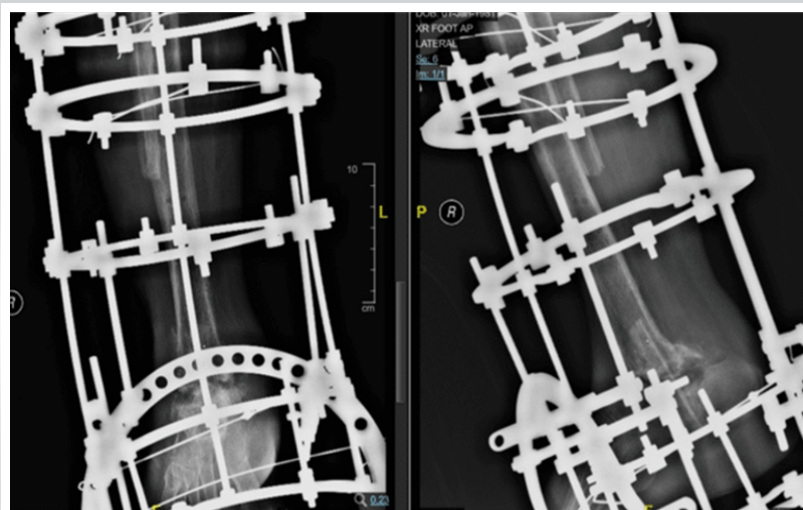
Follow-up anteroposterior and lateral radiographs of the right ankle demonstrating progressive consolidation at the arthrodesis site with Ilizarov circular external fixation in situ.
